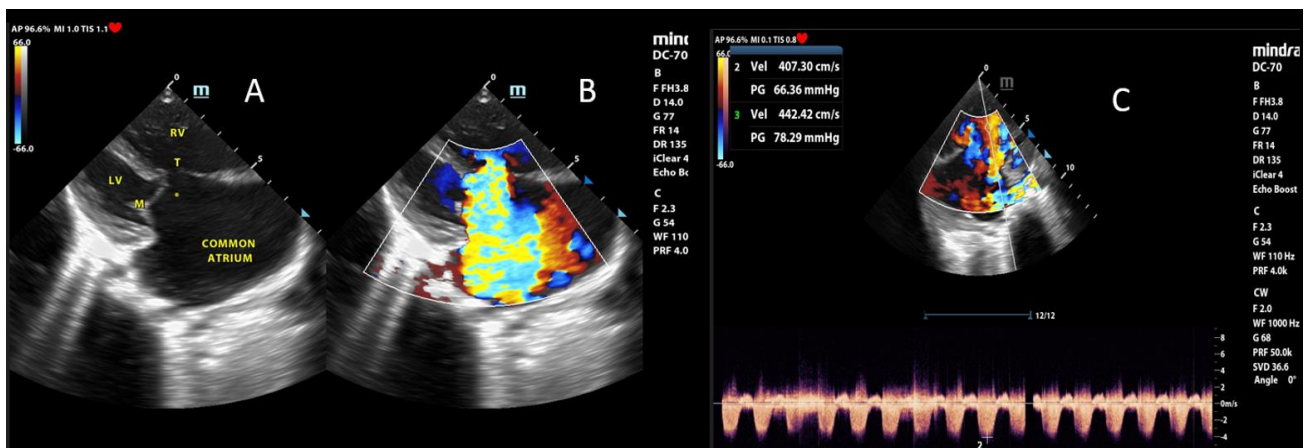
Parasternal Long Axis views, 2D(A) showing common atrium, common atrioventricular canal defect [AVCD] *, two valve orifice [m-mitral orifice and T-tricuspid orifice], flattened septum and slightly large RV than LV. (B) color flow mapping showing severe eccentric atrioventricular valve regurgitation covering approximately more than 50% of the common atrium and directed towards the posterior wall of the common atrium and color Doppler (C) showing tricuspid regurgitation maximum velocity 4.42m/sec and pressure gradient PG 78.29mmHg
